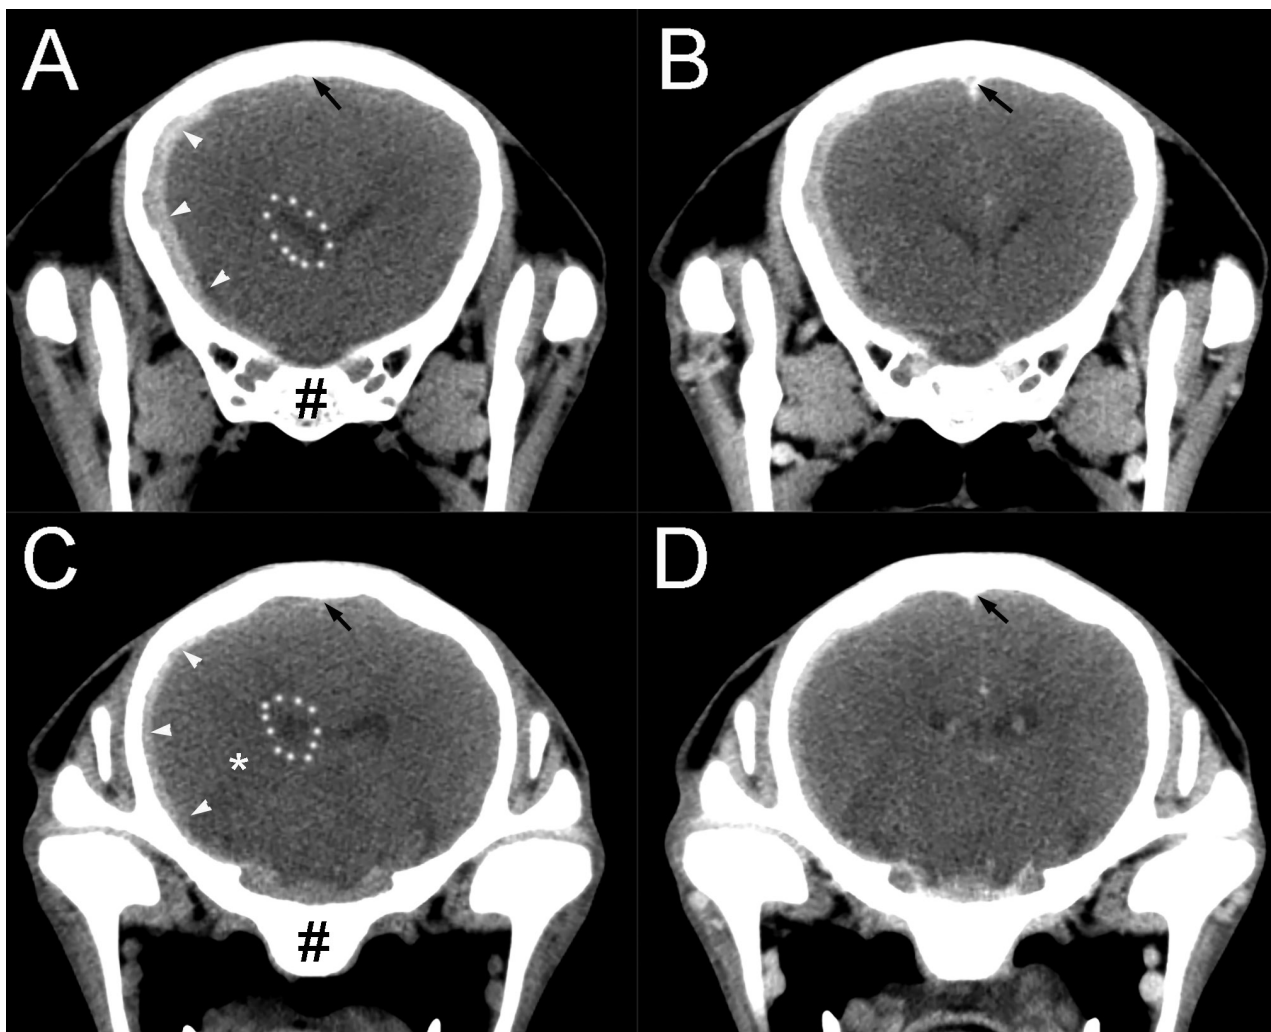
Same CT images as in Figure 1. There is a peripheral crescent-shaped lesion (arrowheads) between the osseous boundaries of the skull and adjacent brain parenchyma. The lesion is hyperattenuating (68 HU; reference range, approx 25 to 30 HU for white matter and 35 to 50 HU for gray matter of clinically normal brains) and extends dorsoventrally from the level of the falx cerebri (black arrows) to the right lateral aspect of the presphenoid bone (pound sign). There is compression and displacement of the right lateral ventricle (within the dotted ovals) and a midline shift toward the left, consistent with a mass effect in the right cerebral hemisphere. The white matter tracts of the right cerebral hemisphere (asterisk) are mildly and diffusely hypoattenuating (18 HU), compared with those of the left hemisphere (23 HU), consistent with vasogenic brain edema. No traumatic bone abnormalities are evident.
